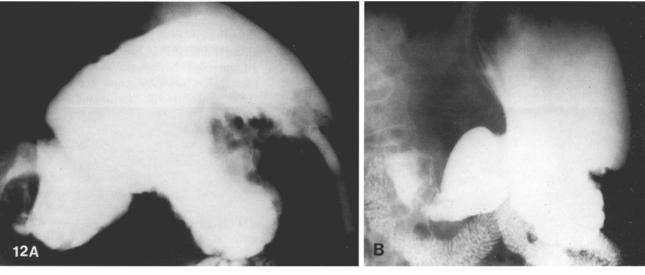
Retrograde jejuno-jejunal intussusception associated with long tube. The coilspring appearance of the dilated intussusceptens and the lumen of the intussusceptum are both demonstrated. (Case courtesy of S. Schwartz, M.D. Connecticut, and *American Journal* of *Roentgenology 125:7*17, 1975)
